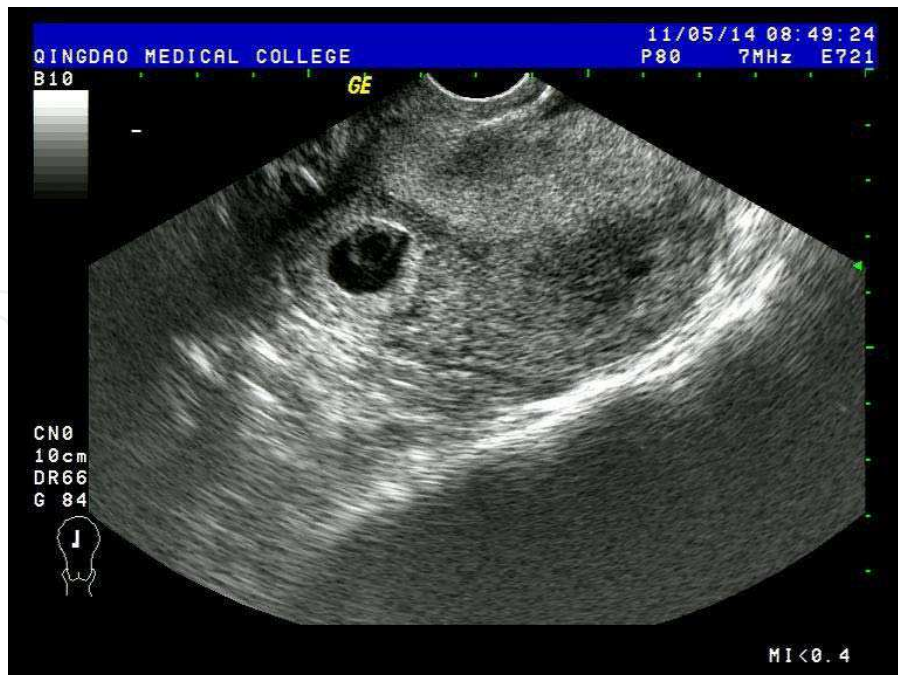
Transvaginal ultrasound image of a cesarean scar pregnancy. Transvaginal scan revealed a 26 mm gestational sac with fetal pole outside the lower uterine cavity at the level of the isthmus in the anterior uterine wall
